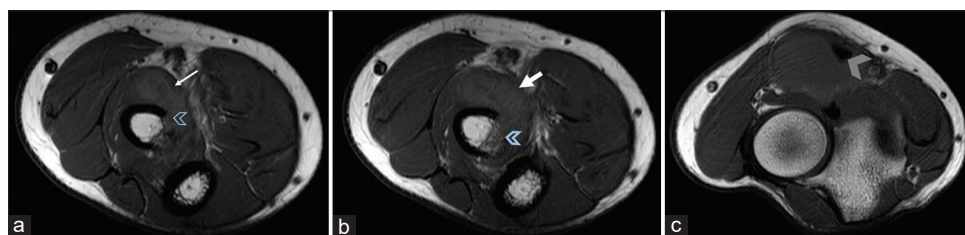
(a-c): Axial T1-weighted MR images of the right elbow showing an isointense, well-defined mass (white arrow) within the supinator muscle and osseous involvement (open blue arrowhead). Encapsulated distal biceps brachii tendon (gray arrowhead)
